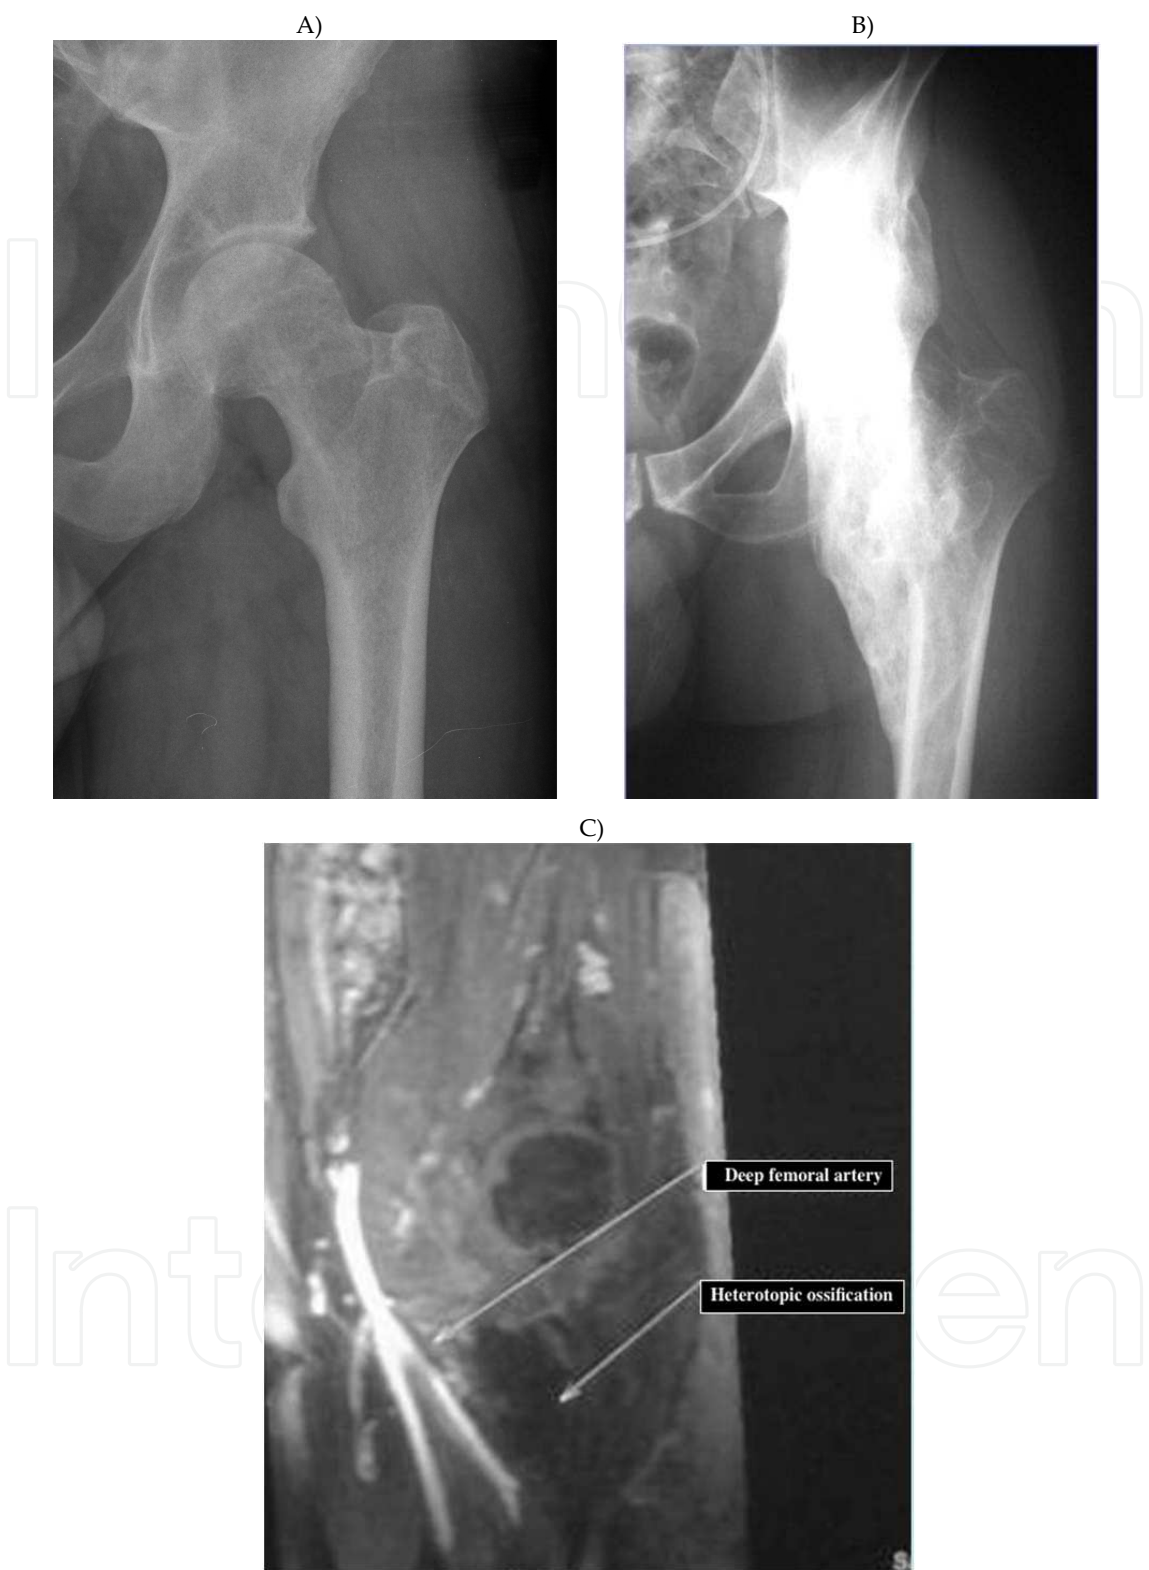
Neurogenic ossification in the hip in a patient after a traumatic brain injury. A) Radiograph of the left hip six months after the brain injury. B) Radiograph showing an anteromedial ossification around the hip causing severe ankylosis, 14 months after the initial injury. C) MRI enhanced with contrast showing a close relationship between the ossification and the deep femoral artery.
